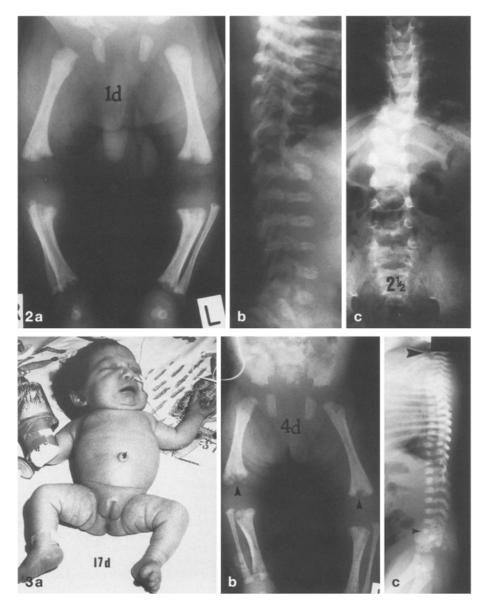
Case 2, plain radiographs. a, b One day old. a Transradiant metaphyseal defects, characteristic of enchondromatosis.
